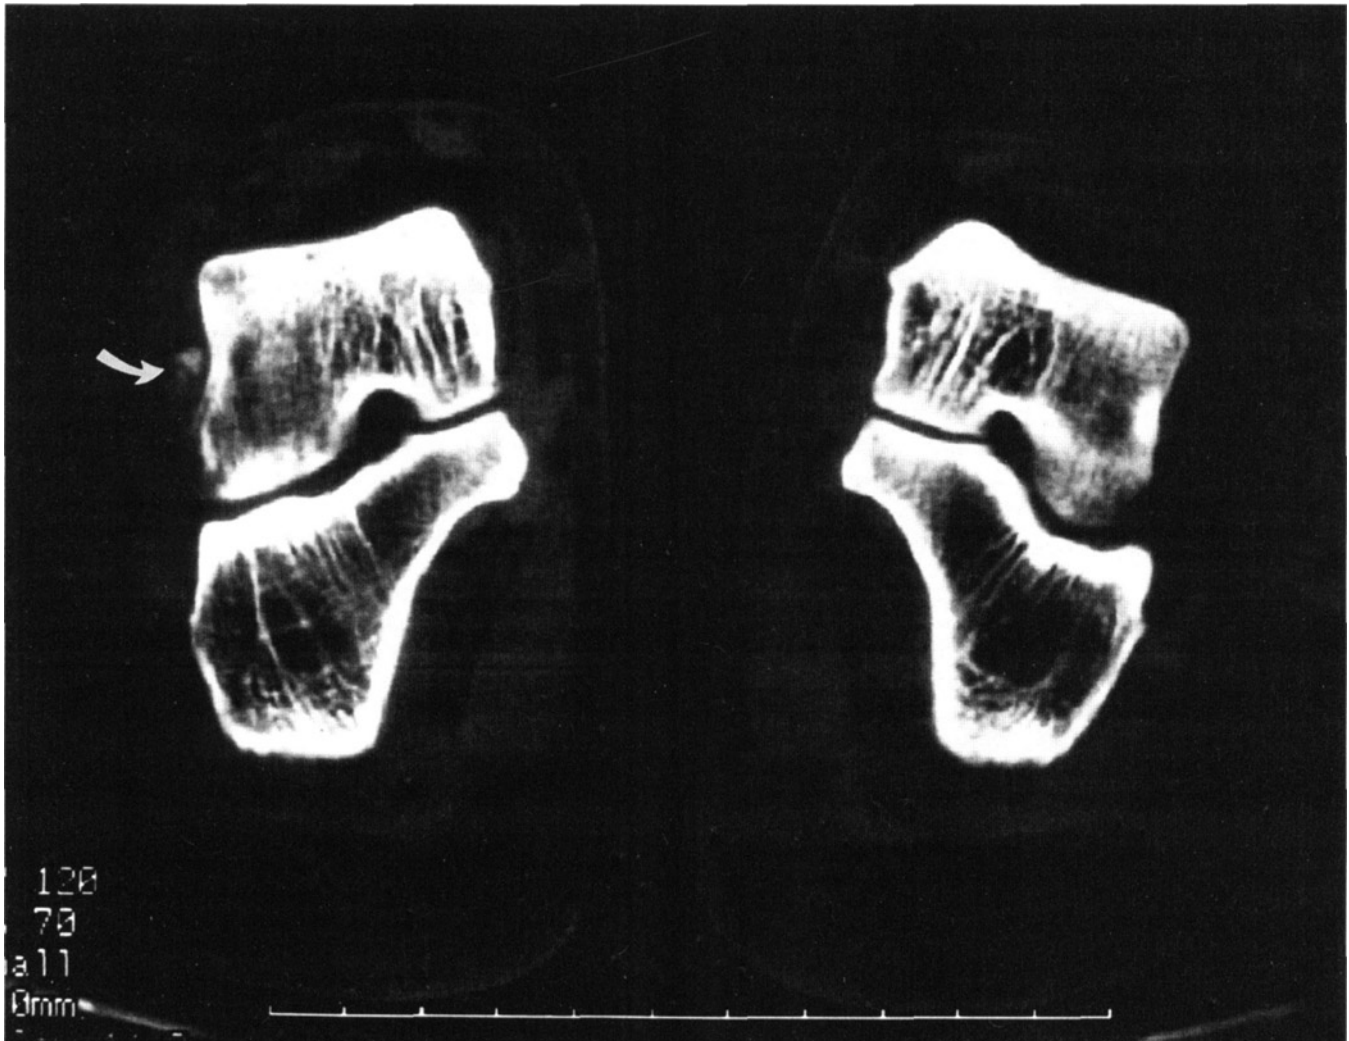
Semicoronal cut of CT scan showing the large bone exostosis at the insertion of the ATFL.
